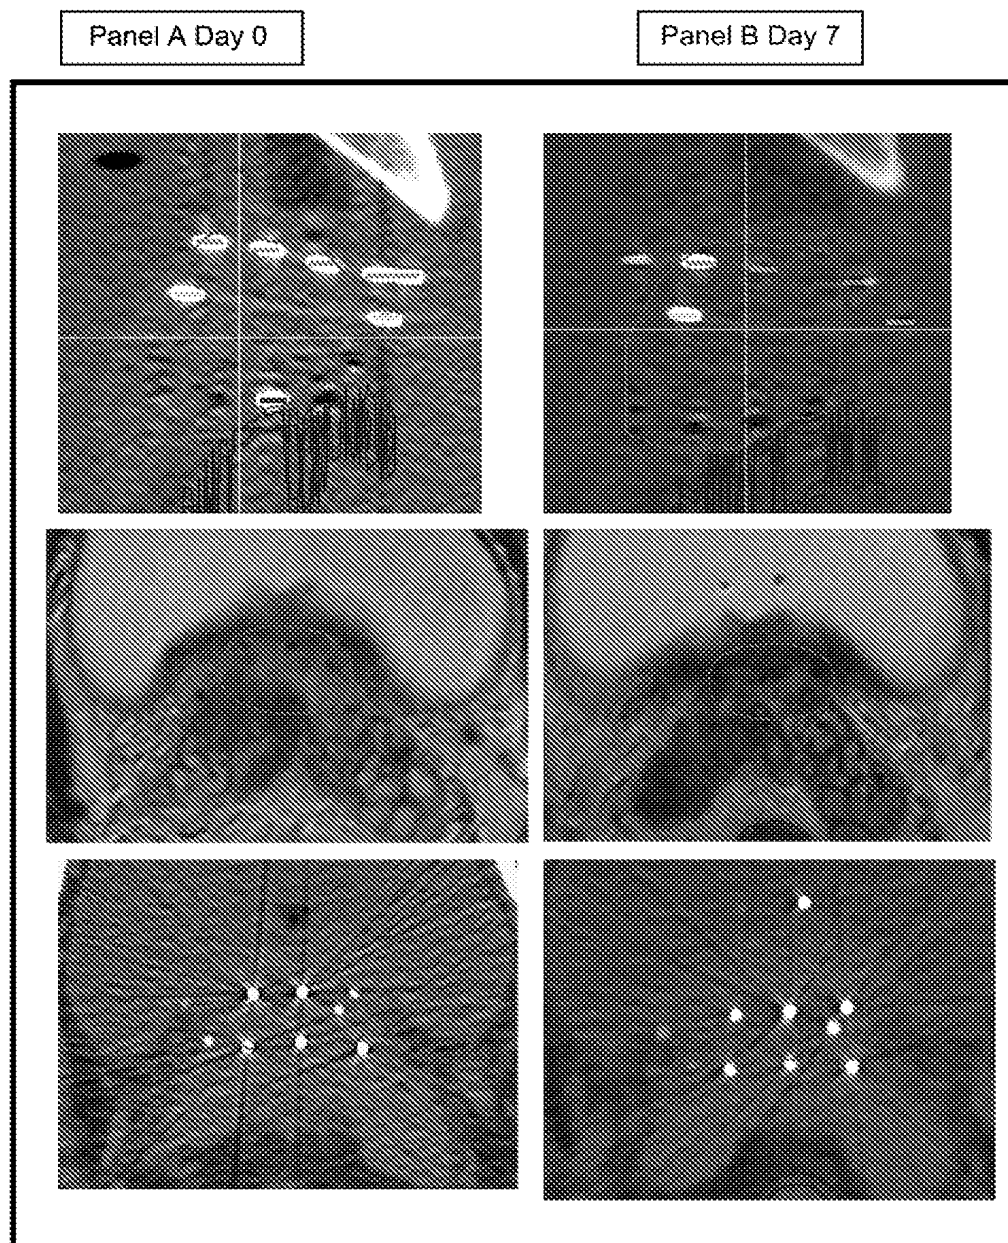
(Panel A) Images from Day 0 scans. (Panel B) Images from Day 7 scans. (Top) Two-dimensional reconstruction from computed tomography scan showing specially loaded five-seed strand (double-loaded at apical end; all seeds stranded). Between Days 0 and 7, cranial movement of strand into bladder seen. This was one of two strands that migrated cranially in this patient. (Middle) Magnetic resonance imaging scan slice near prostate base. Strands seen in bladder on Day 7. (Lower) Computed tomography images at same level as magnetic resonance images.
